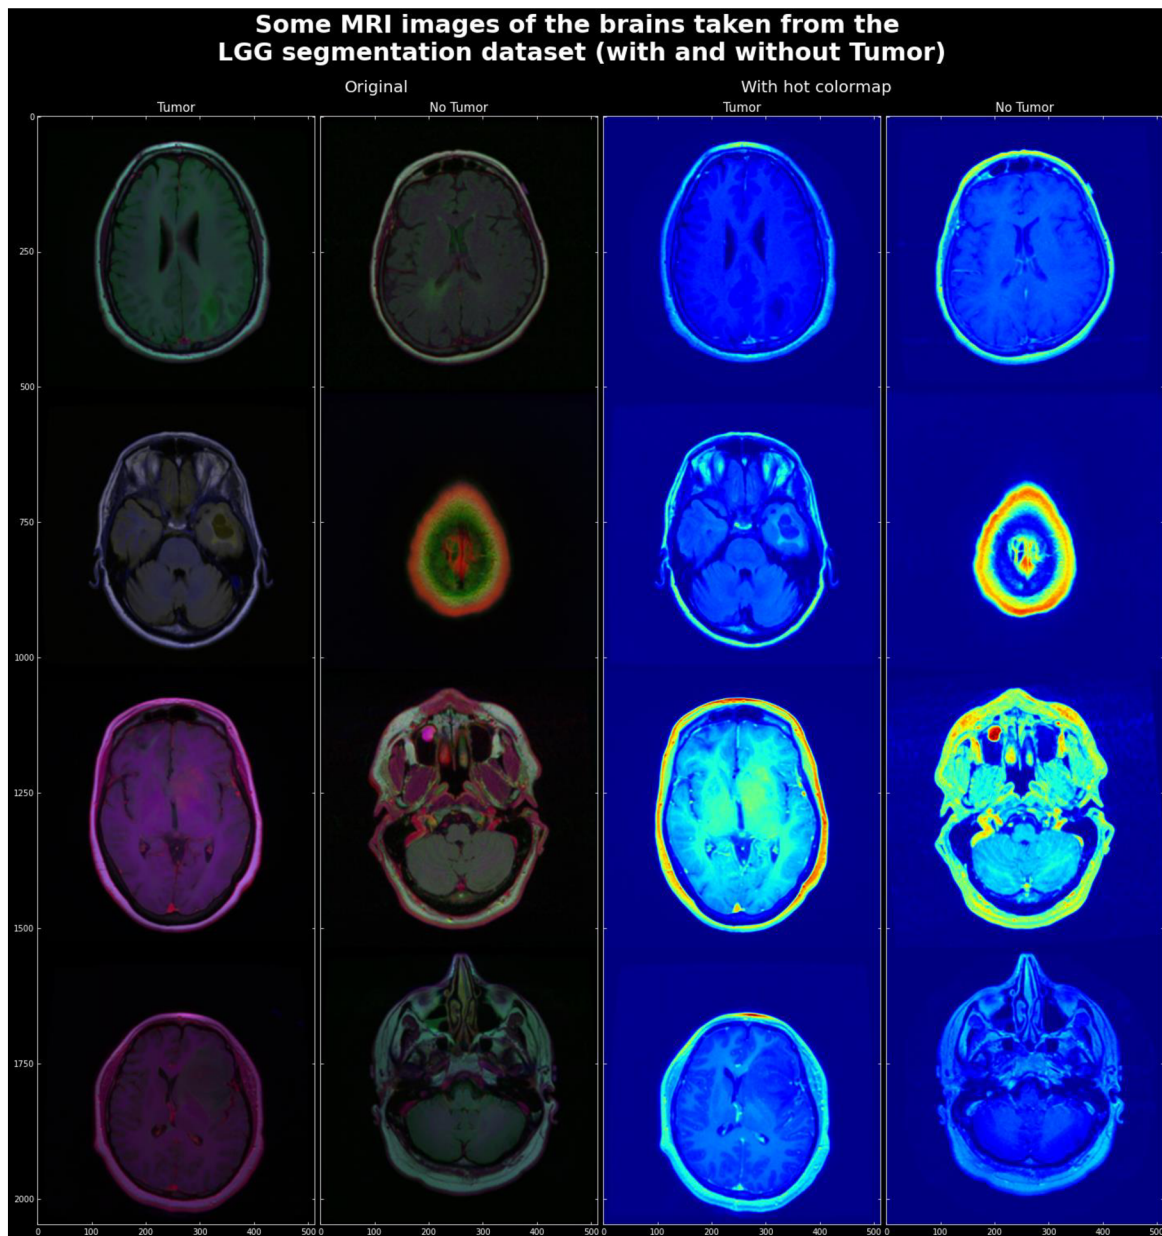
MRI images of the brains with and without tumors (*Brain MRI Segmentation*, n.d.). A color map is used here to reveal relevant features to human eyes, such as skull border and tumor area. (Own work).
